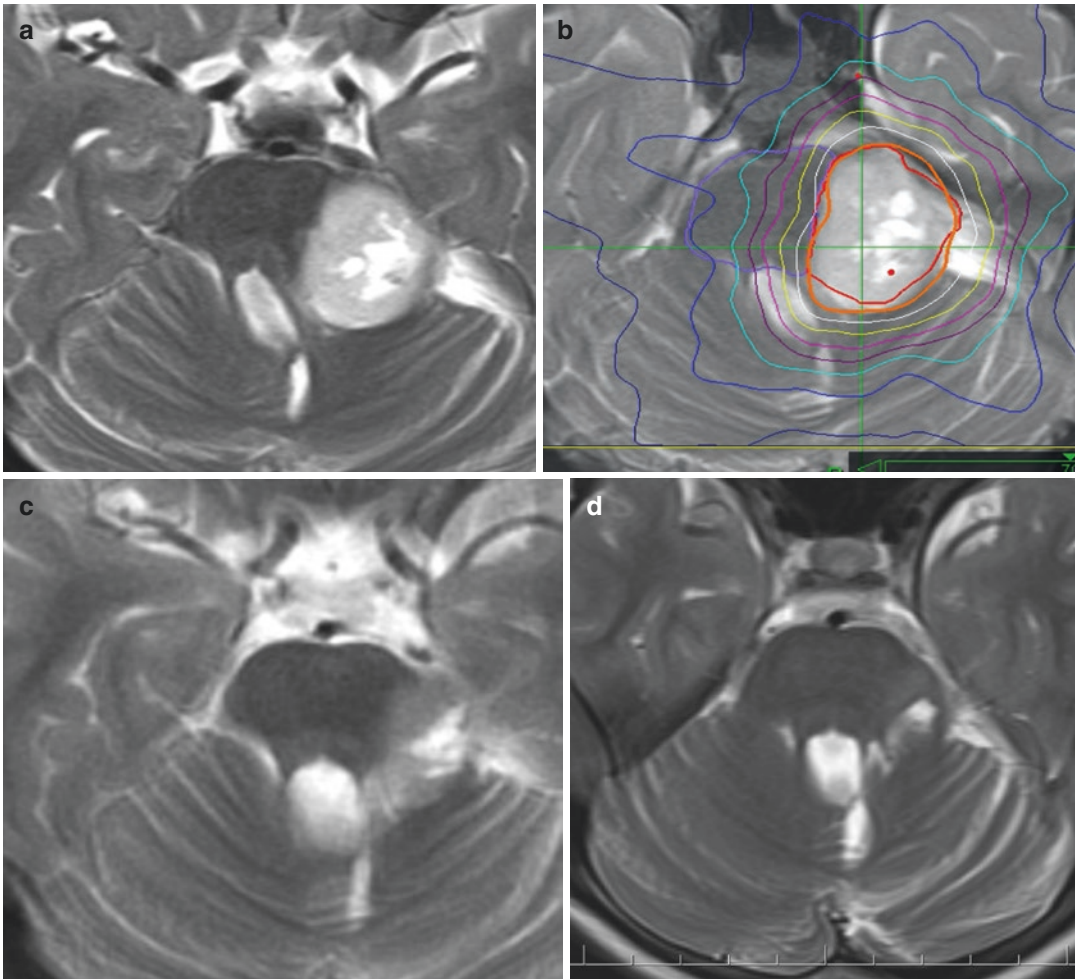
(a) 3 months post-surgical MRI of a 5-year-old patient with residual pilocytic astrocytoma (b) A hFSRT course was planned using the CyberKnife. Target volume (CTV = PTV = 12.32 cm³). Six fractions × 5 Gy were
